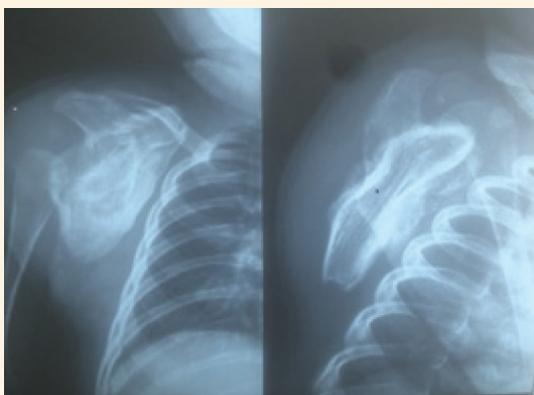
X-ray images of the right shoulder of a three-month-old male infant showing diffuse scapular periosteal reaction with subperiosteal new bone formation.
